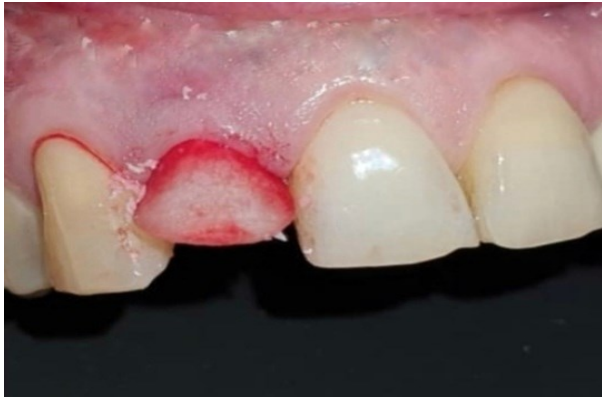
Extracted tooth#7 with periapical lesion. A temporary Maryland bridge is prepared to guide soft tissue healing.
